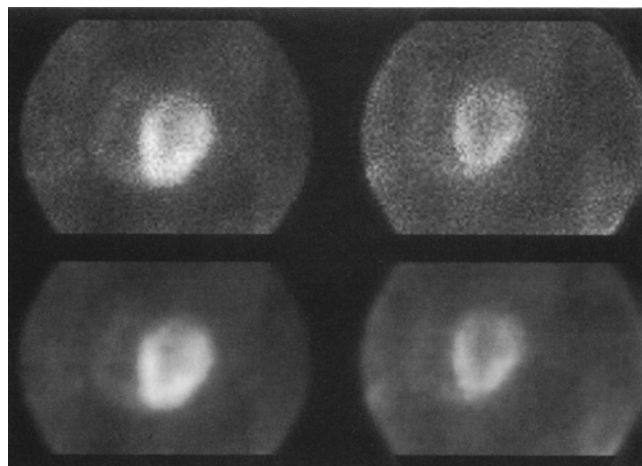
Original stress and delayed ^{201}Tl planar cardiac perfusion scintigrams shown in top row. Smoothed versions shown underneath in the second row.
